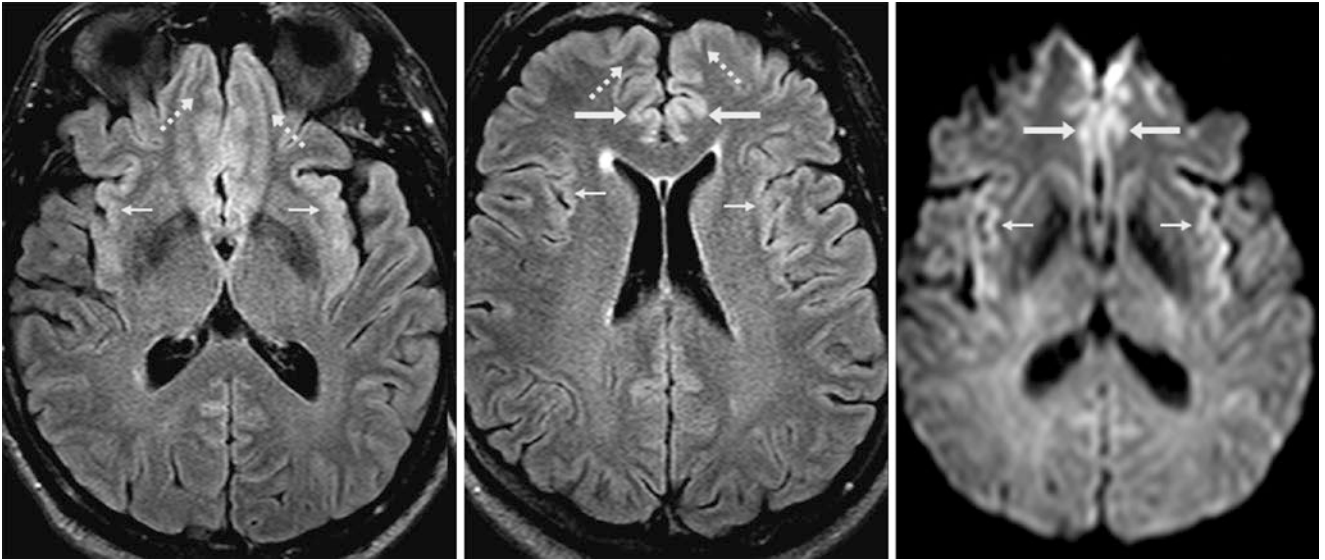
A 64-year-old underwent a 3 T MRI that demonstrates hyperintense cortices of the cingulate (*arrows*), insular (*thin arrows*), and orbitofrontal (*dashed arrows*) gyri on axial FLAIR images (*left and*
